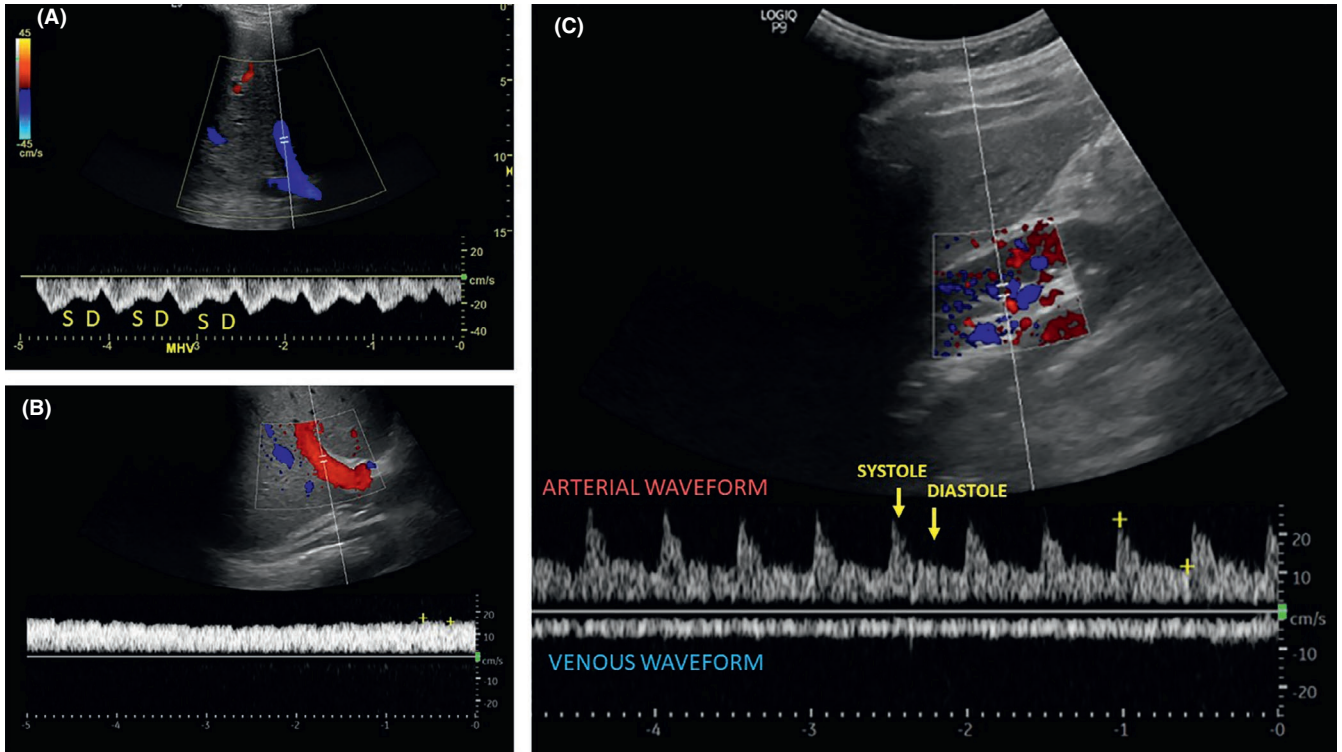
Normal hepatic vein (A), portal vein (B), and intrarenal vein (C) Doppler waveforms. S = systolic wave, D = diastolic wave. Note that the normal flow is below the baseline in hepatic and intrarenal veins, while it is above the baseline in portal vein
